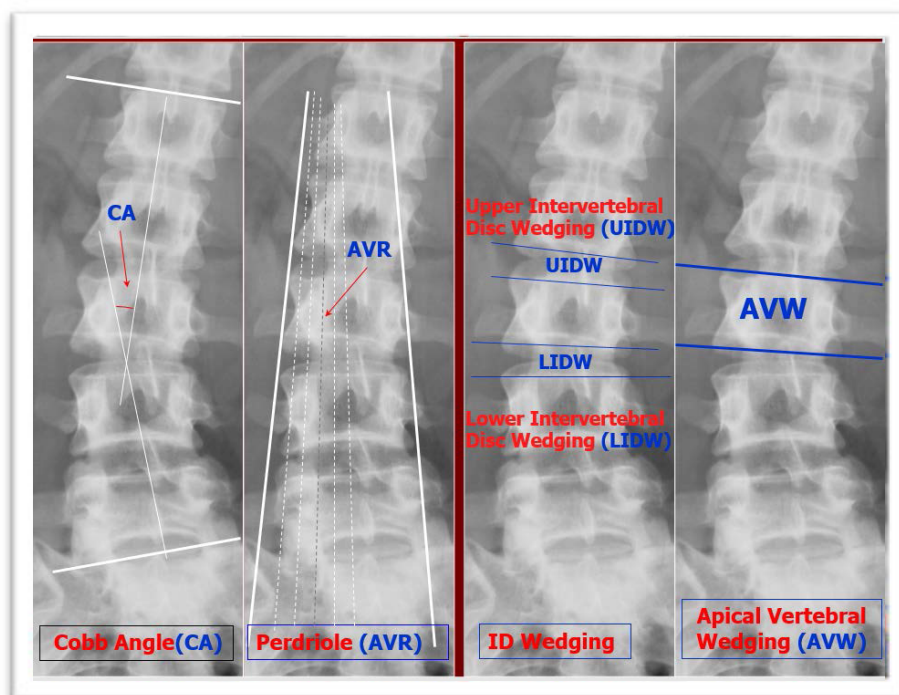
The readings on the PA radiographs Cobb angle (CA), apical vertebral rotation (AVR), apical vertebral wedging (AVW) and the adjacent to the apical vertebra Upper (UIDW) and Lower (LIDW) Inter-Vertebral Discs Wedging.⁵
